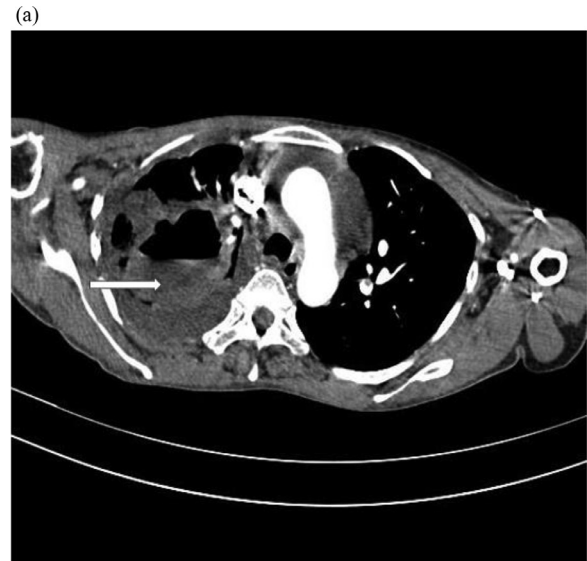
(A) CT scan of the thorax showing: Thick walled cavity with mass lesion in the upper lobe of the right lung. (B) * Hypodense filling defect in the left ventricular cavity, Pericardial effusion and White arrows depicting bilateral pleural effusion.
